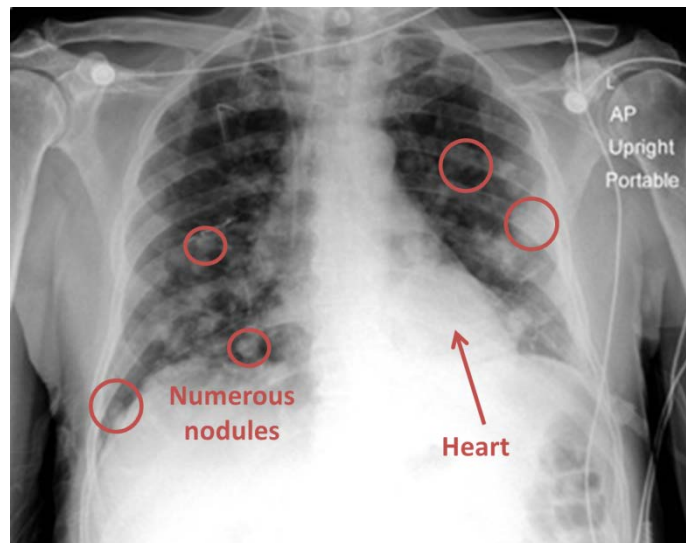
AP x-ray demonstrating leiomyosarcoma metastasis to lung. University of Massachusetts Medical School, Department of Radiology.
